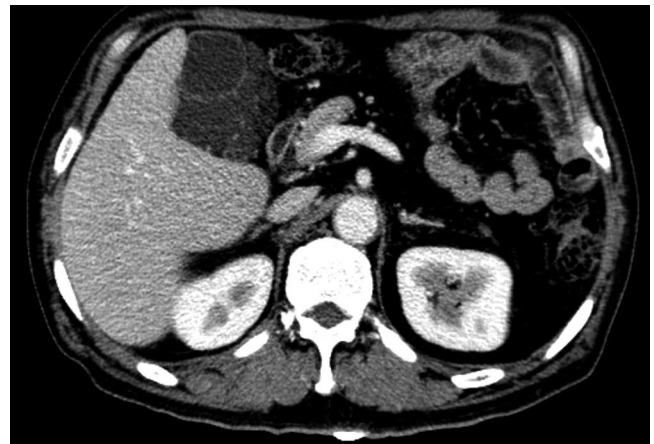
Abdominal computed tomography (CT) image showing a low-density multilocular cystic lesion with septation originated from the gallbladder fossa.
